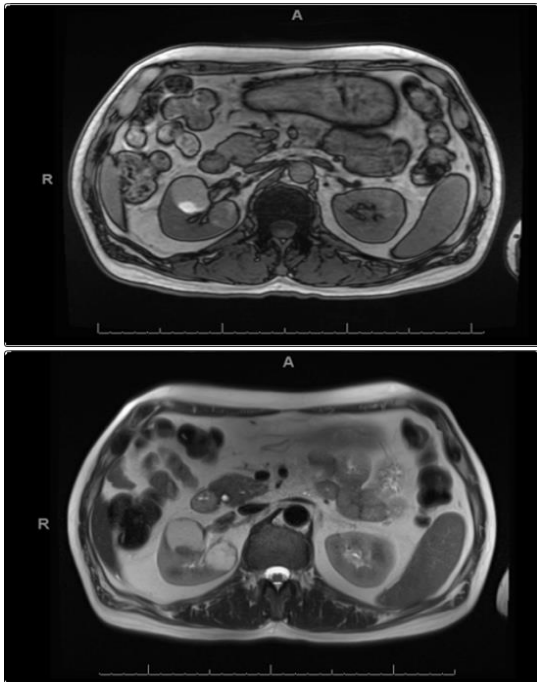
MRI both kidneys T1 signal (Top) and T2 signal (Bottom). The more anterior cyst contains an area of T1 high signal posteriorly which does not enhance appreciably and would be consistent with proteinaceous/haemorrhagic debris. The more posterior lesion demonstrates multiple septations.
